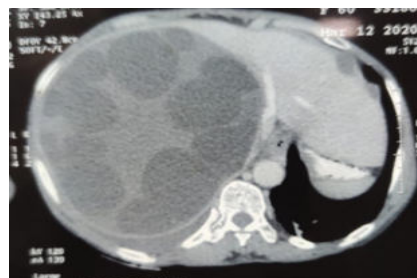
Contrast enhanced CT scan showing hydatid cyst of right lobe of liver
